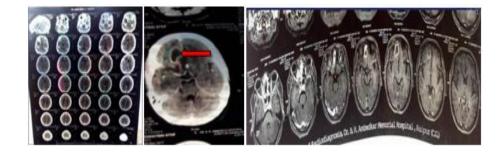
(CECT Head) Fig.2 (CECT Head) Fig.3 (MRI Brain P+C)
